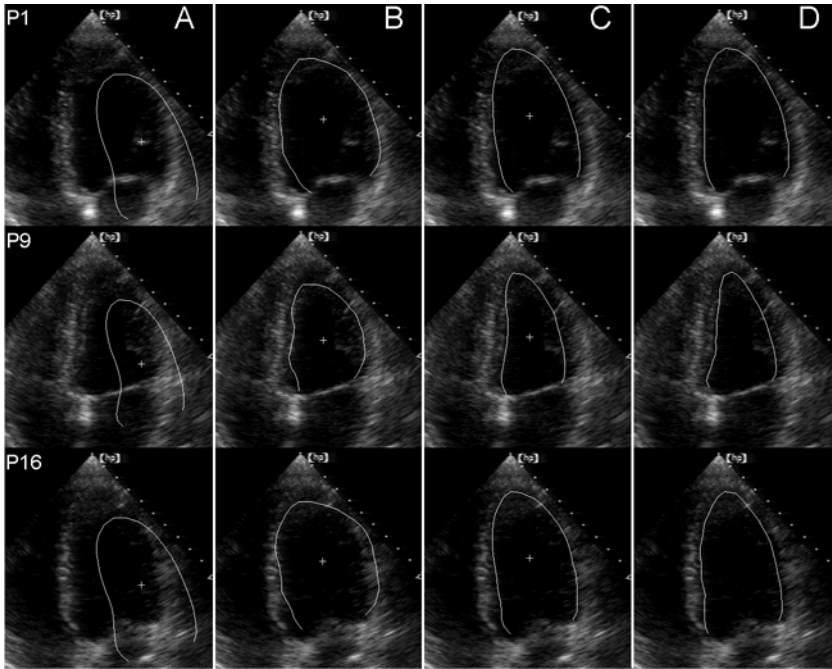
Example result of fully automated AAMM segmentation of an echocardiographic image sequence from the test set, spanning over one heartbeat. Segmentation was performed simultaneously in all 16 image phases. From top to bottom, partial images from phase 1, 9, and 16 are shown. A. Initial 16-phase AAMM model positioned on phase images 1, 9, and 16. B. AAMM match after five iterations. C. Final match after 20 AAMM iterations. D. Observer-identified endocardial contours shown for comparison.
